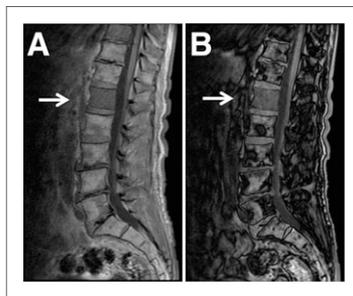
In-phase (A) and out-of-phase (B) MR images, with the latter showing no significant decrease in signal in L1 vertebral body (arrows).
